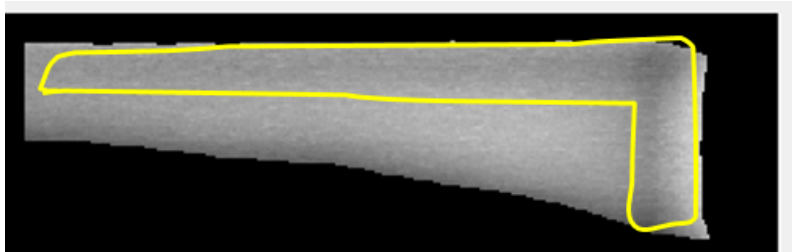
Example of the primary X-ray beam shadow, that appears as an image frame on the background areas around the patient.
